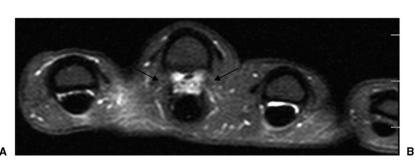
Axial image at the level of the A2 pulley from magnetic resonance imaging of the middle digit. There is complete disruption of the A2 pulley (arrows), with palmar displacement of the flexor tendon. A The intact pulley is present in adjacent digits. B Sagittal image of the middle digit demonstrating palmar displacement of the flexor tendon.
